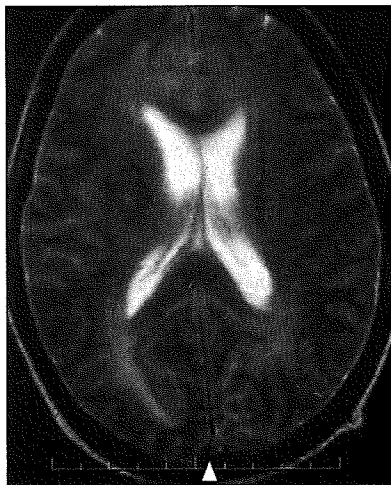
55-year-old woman with venous sinus occlusion on 72nd day after hematopoietic stem cell transplantation (HSCT). T2-weighted MR image shows loss of flow void in superior sagittal sinus (*arrowhead*). Bilateral ill-defined diffuse hyperintensity is present in periventricular white matter, possibly indicating vasogenic edema due to venous congestion.
